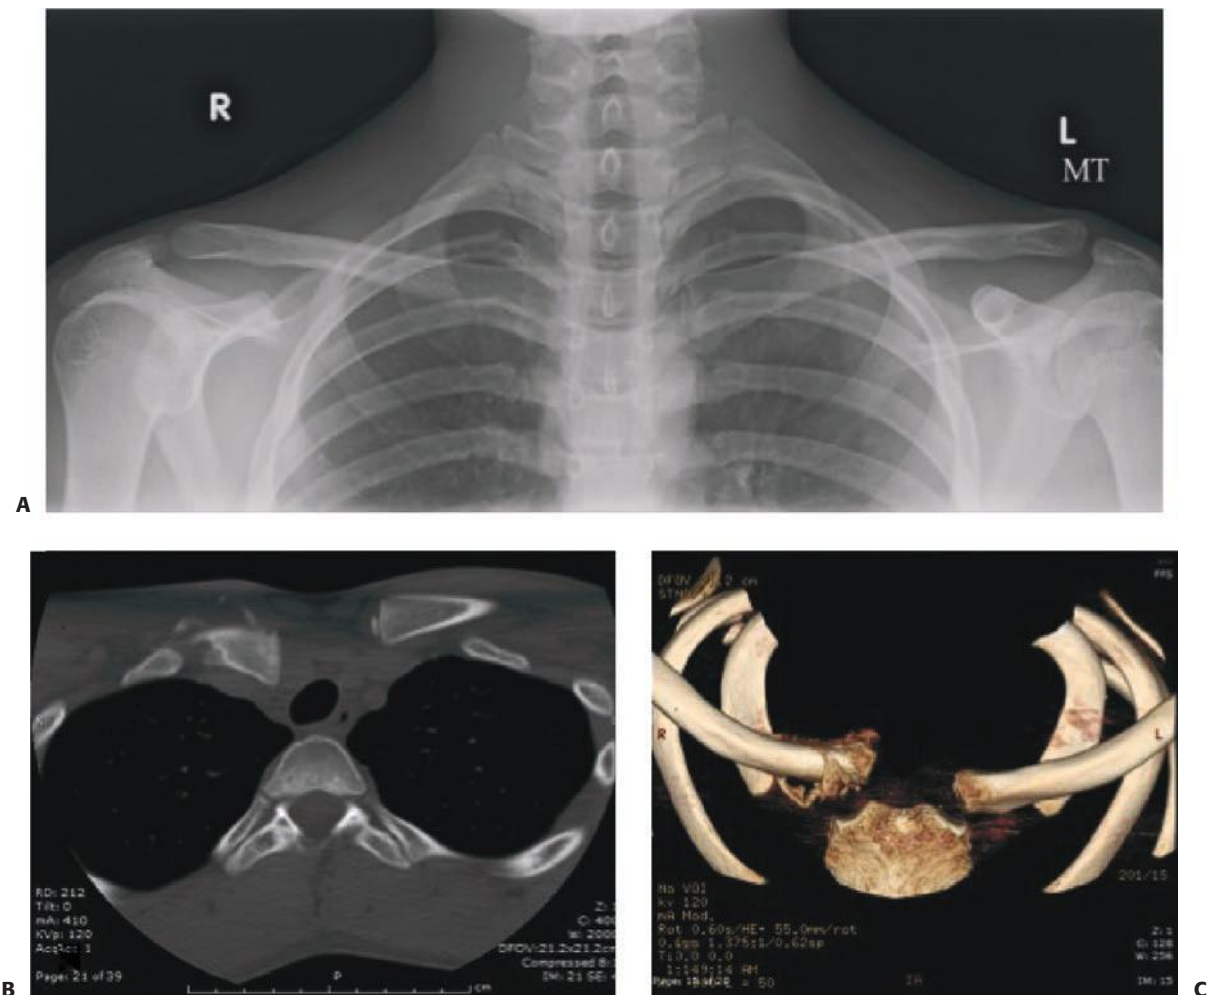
A: AP view of both clavicles does not demonstrate any obvious abnormality. B: Computed tomography 4 weeks later demonstrates posteriorly displaced proximal clavicle fracture, more fully appreciated on three-dimensional reconstruction (C). (Used with permission from the Children's Orthopaedic Center, Los Angeles.)
